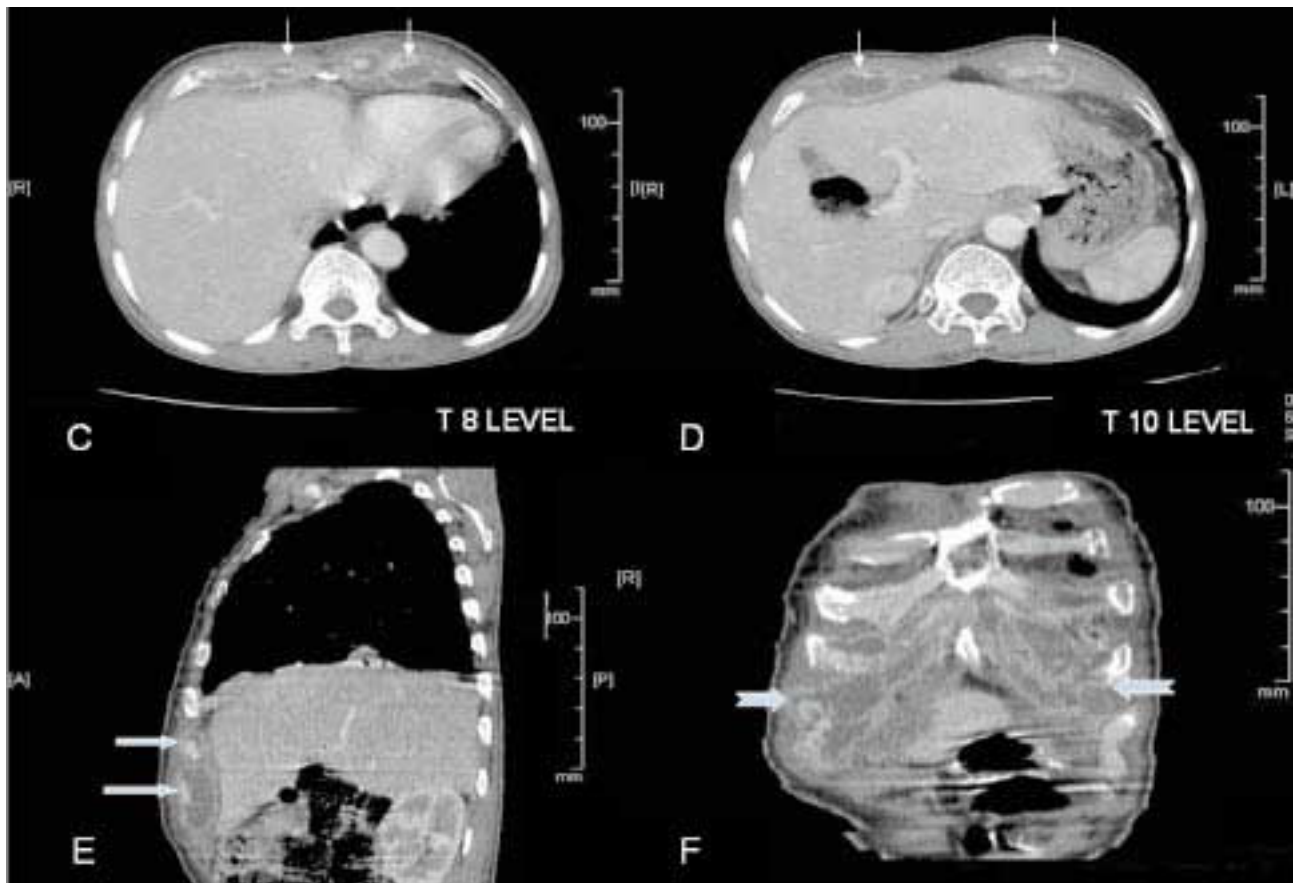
Contrast enhanced CT images of thorax.
